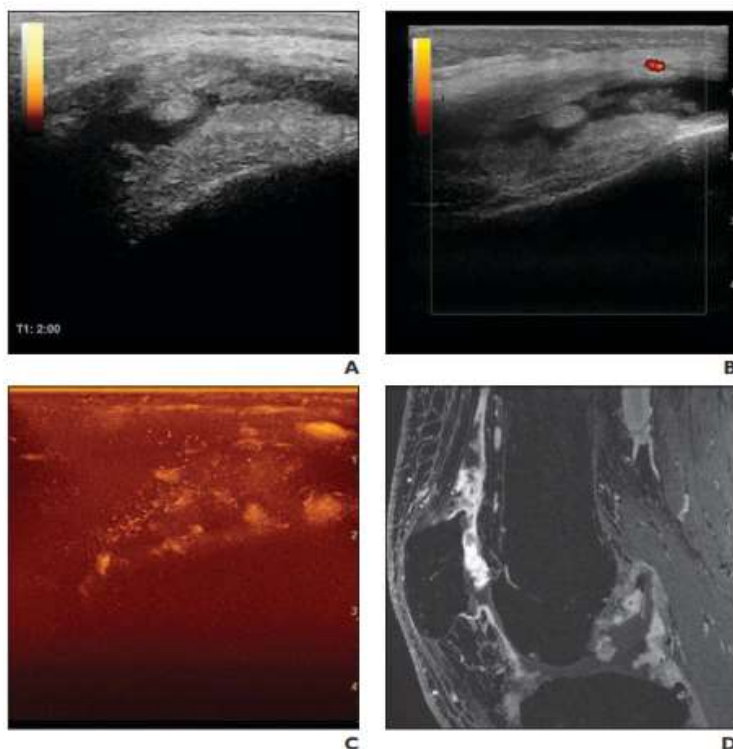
Figure 2. Ultrasound and contrast-enhanced MRI findings in a patient with Kellgren-Lawrence grade 3
